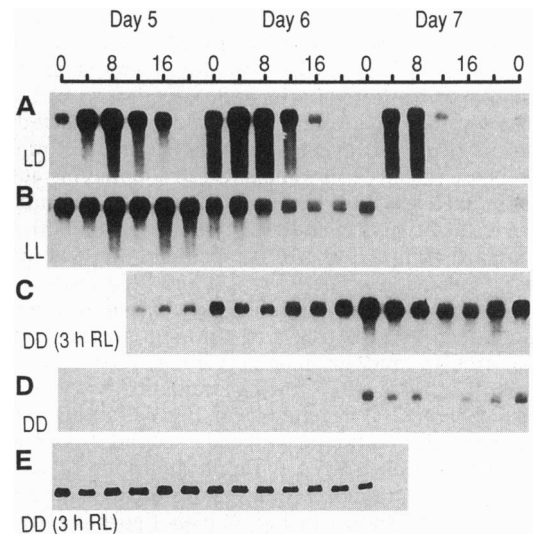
Circadian clock regulates the accumulation of Cab mRNA (A–D) but not that of the *PhyA* mRNA (E) in 5- to 7-day-old tobacco seedlings. Seedlings were grown under 16-h light/8-h dark cycles (LD) (A), grown in constant light (LL) (B), irradiated for 3 h with red light [DD (3 h RL)] immediately after sowing but returned to constant darkness for growth (C and E), and grown in constant darkness (DD) (D). Numbers indicate the CT based on a value of \approx 24 h for τ (period length of the circadian rhythm). Seeds were uniformly sown at the hour of 0800 (CT0). Each lane contains 10 μ g of total RNA (A and B) or 20 μ g of total RNA (C–E). Filters were exposed for 48 h (A and B) or for 96 h (C–E).
